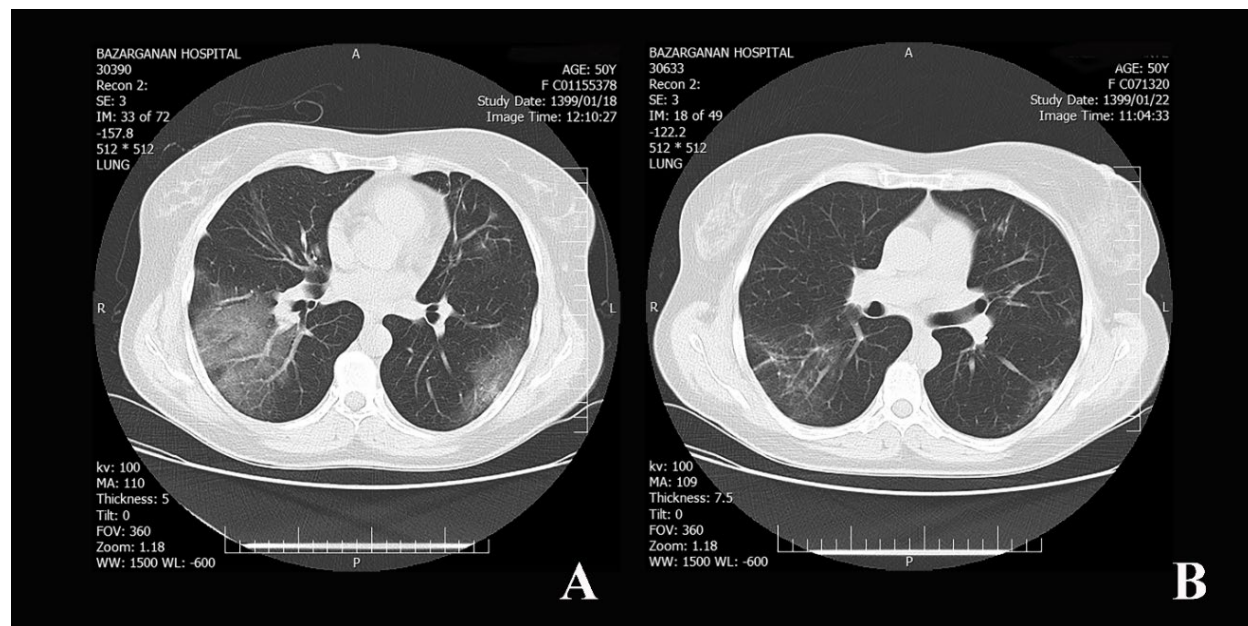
Spiral lung CT-scan of a 50 years old patient with COVID19; A: Apr 6, 2020; B: Apr 10, 2020
